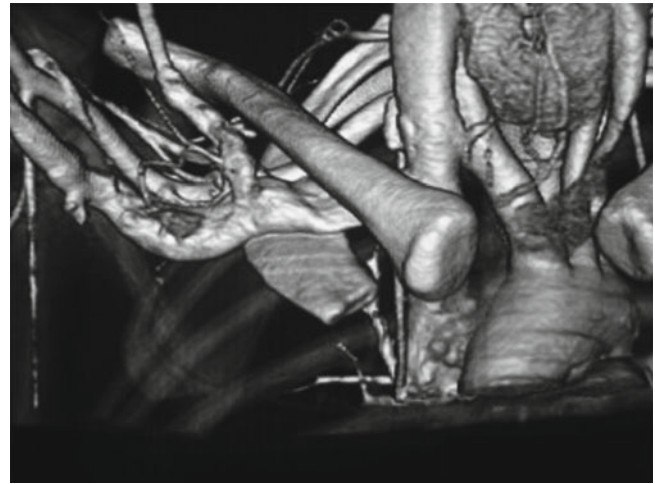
Computed tomography scan of the right shoulder, viewed from an anterior projection, with soft tissues such as the subclavius muscle subtracted out. The right arm is elevated. Note compression of the subclavian vein as it passes between the clavicle and the first rib (Courtesy: Wallace Foster, MD, Brisbane, Australia; Reprinted from Glass et al. [25], with permission)
